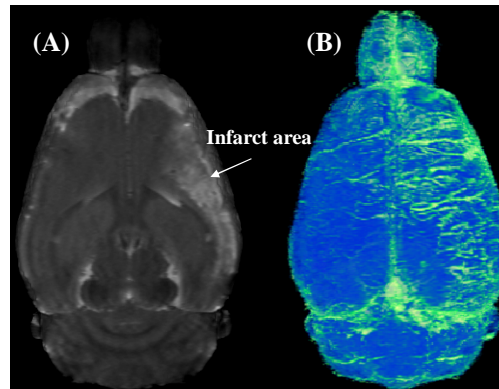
(A) T2-weighted imaging showing the infarct area in ipsilateral side at day 7 after reperfusion. (B) 3D mMRA showing the vessel distribution on the brain surface after reperfusion.
